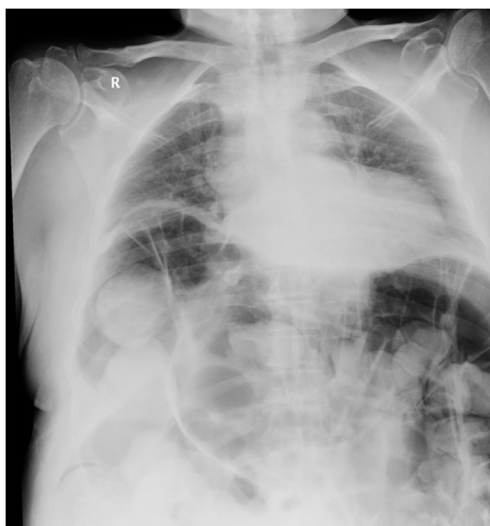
Chest X-ray on presentation showing Chilaiditi sign and lungs compressed.
